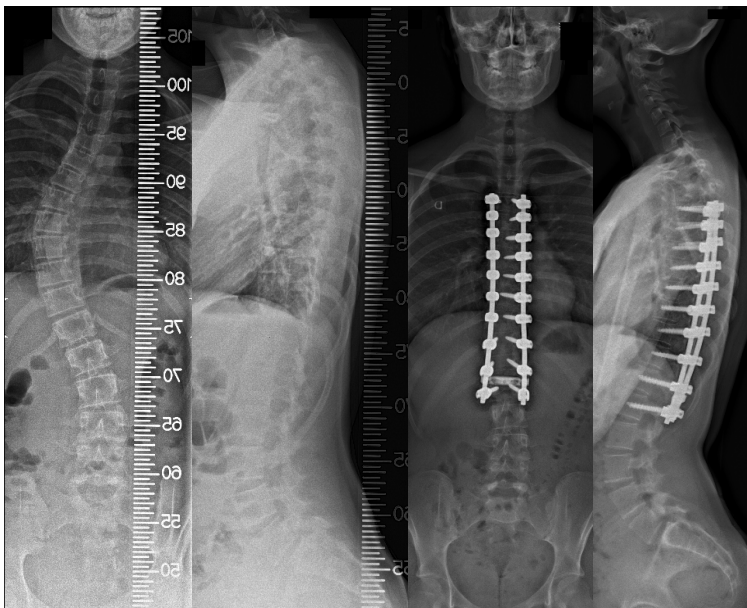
Reinforced rod instrumentation: Figs. 4-A to 4-D. 15-year-old boy with adolescent idiopathic scoliosis. Preoperative standing radiographs (A, B) demonstrate 45-degree thoracic scoliosis with hypokyphosis. Standing radiographs at two-year FU (C, D) demonstrate sagittal reinforced rod instrumentation with normal thoracic kyphosis.
